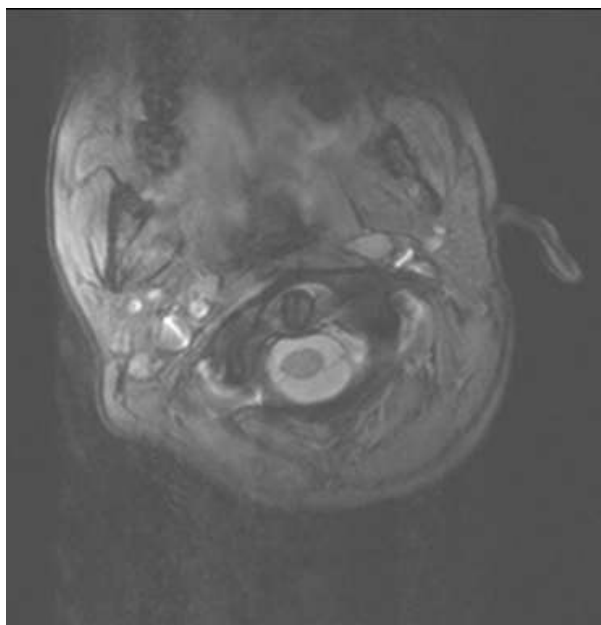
MRI (own source, department of radiology Uniklinik)
